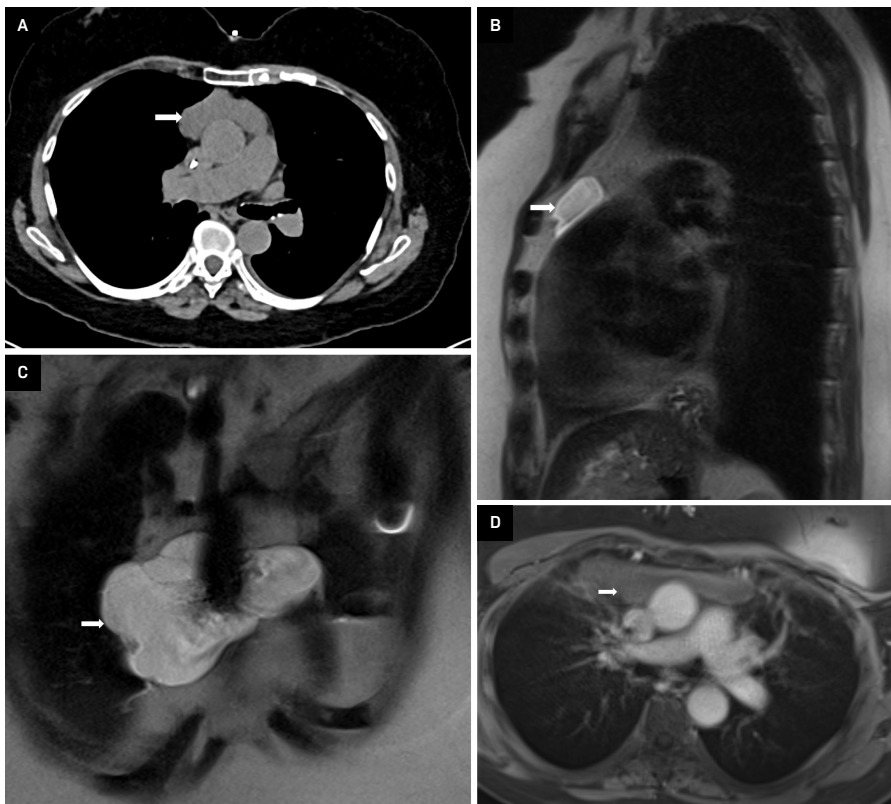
Thymic cyst. (A) Axial noncontrast CT chest image shows a low-attenuation lesion in the prevascular space. (B, C) Sagittal and coronal T2-weighted MRI images demonstrate the craniocaudal extent of the multilocular lesion with heterogeneous T2 signal, reflecting variable fluid composition across the cystic locules with internal septations consistent with a thymic cyst. (D) Axial post-contrast T1-weighted MRI image shows no enhancement of the lesion in the prevascular mediastinum.
